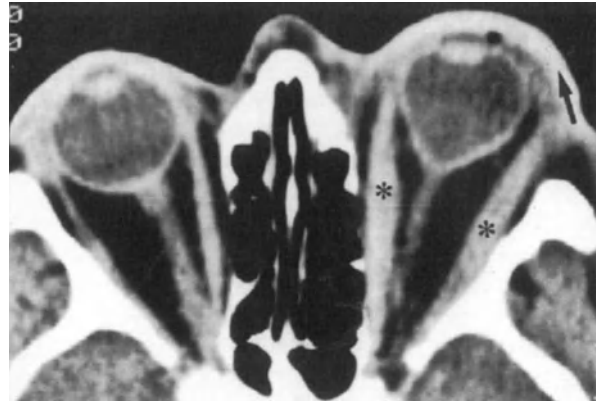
Axial CT scan at the orbital level in a patient with severe exophthalmos of the left eye which occurred after excision of a disc herniation in a stenotic spinal canal. The image reveals a thickening of the rectus medialis and lateralis muscles (asterisks), of the left subpalpebral tissue (arrow) and dysmorphia of the eyeball.
